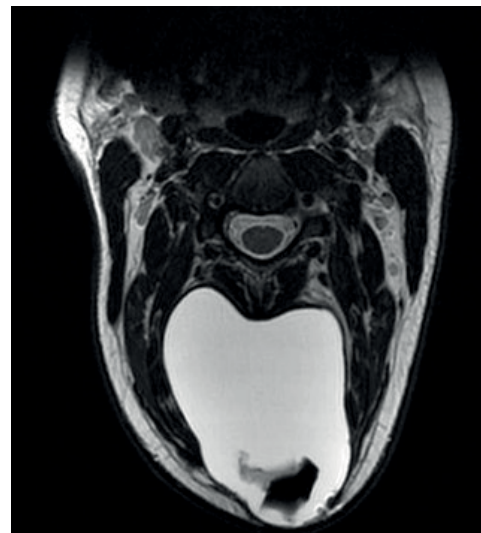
(Above): MRI on arrival.
